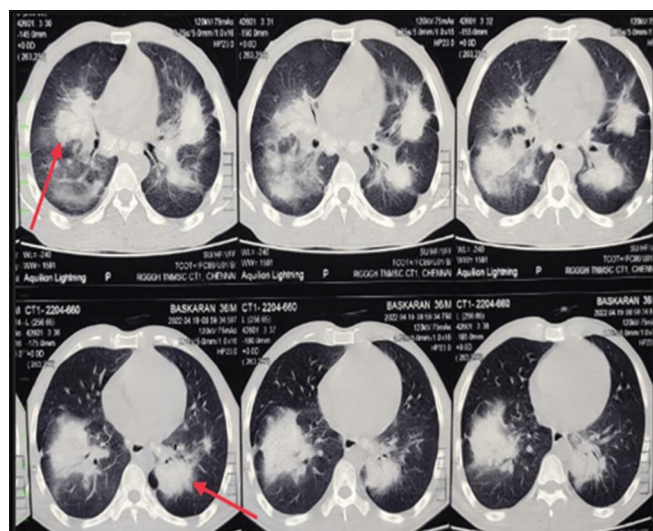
Contrast computed tomography chest showing bilateral calcified lymphadenopathy with progressive massive fibrosis
